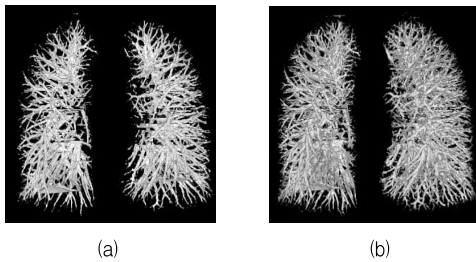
Lung and Airway Segmentation in Chest CT
